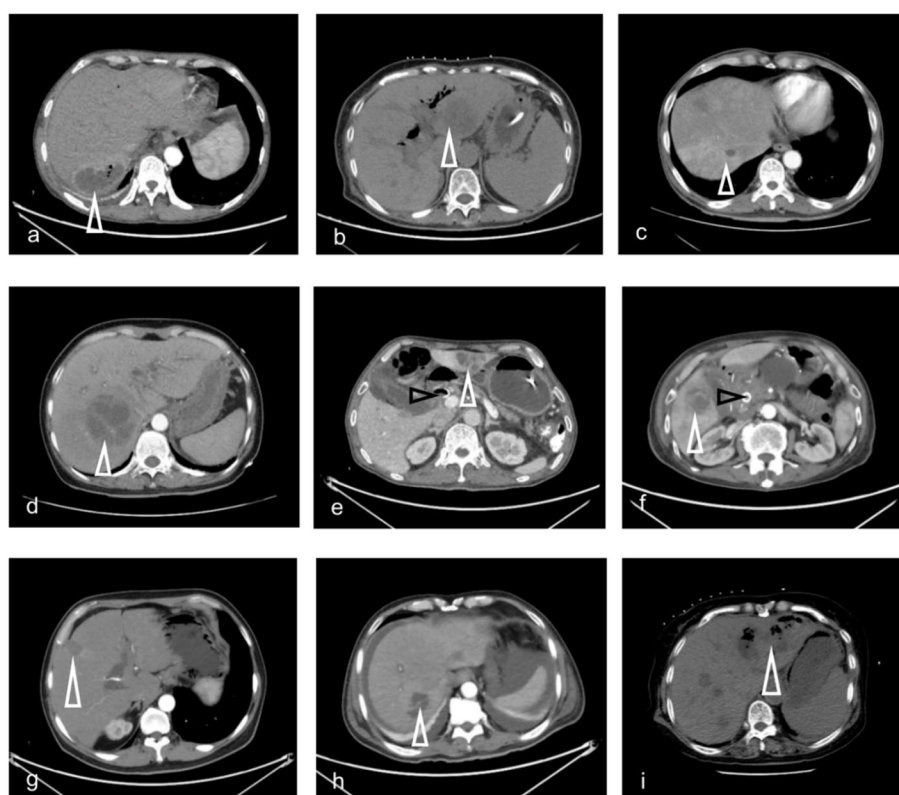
CT images of 9 PLA patients. The black arrows indicate the biliary stent. The white arrows indicate the PLA lesions, which typically present as hypoechoic areas in the liver with possible peripheral enhancement. Images (a) and (i) show gas within the abscess. Image (c) corresponds to a patient with a small PLA lesion who did not undergo puncture treatment. Image (f) corresponds to a patient who received RFA treatment postoperatively, with the PLA developing in the original RFA treatment area one month later)
